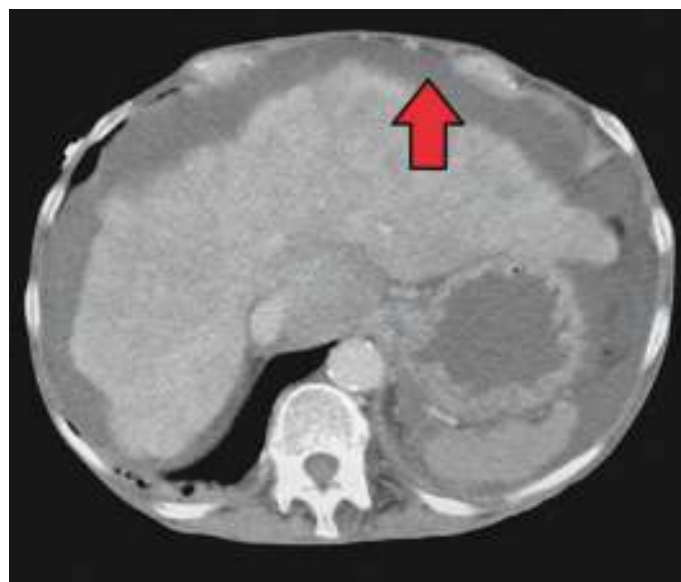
Computed tomography image of the abdomen with ascites (arrow). (Used from www.commonswikimedia.org.)
